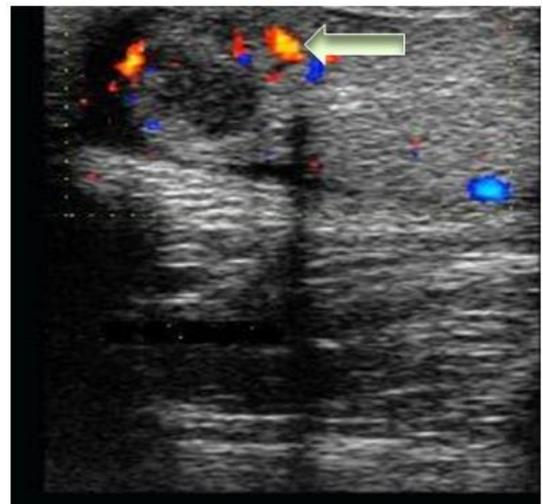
b: Colour Doppler shows focal increase in vascularity (Colour Doppler Image)
